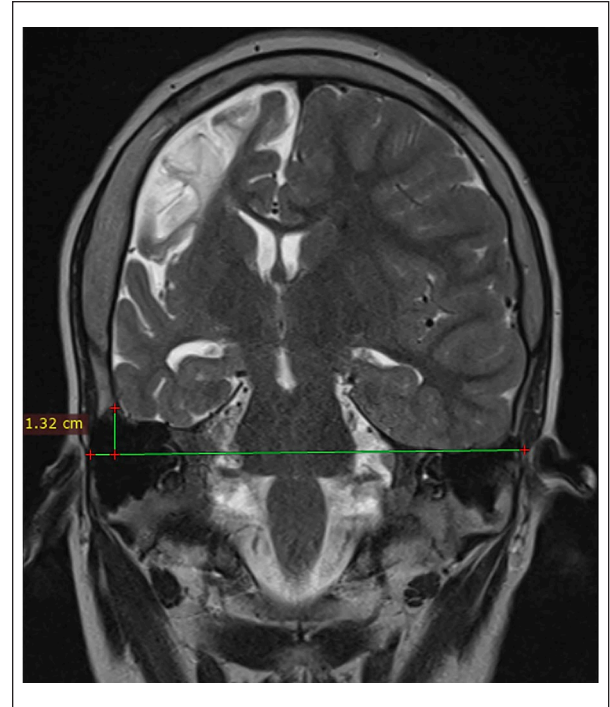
Coronal T2 sequence of MRI showing an elevation of the right petrous ridge (Affected side).
